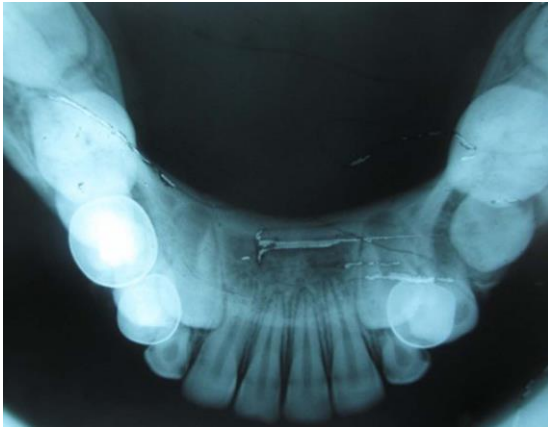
Occlusal radiograph showing no expansion of cortical plates in 84, 85 area
